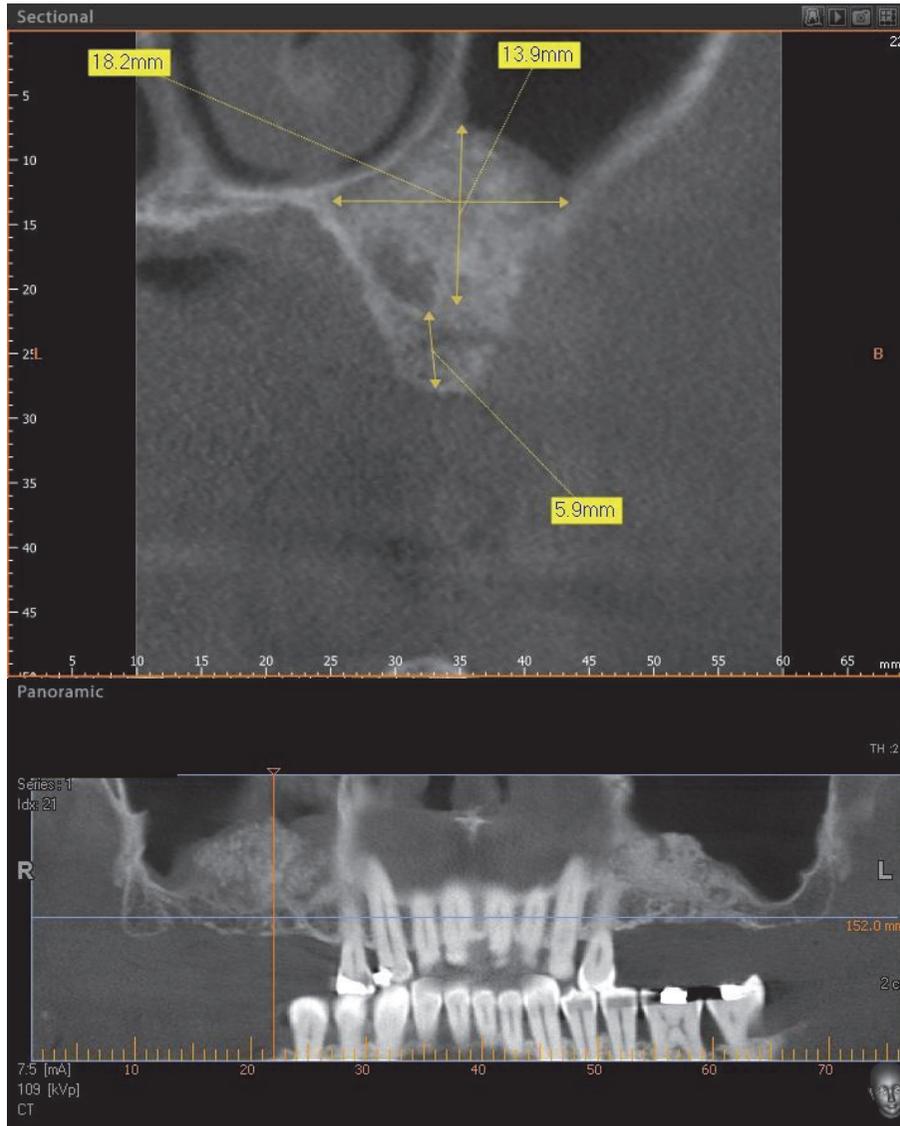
Postoperative CBCT scan panoramic view at 6 months after maxillary sinus lifting.
